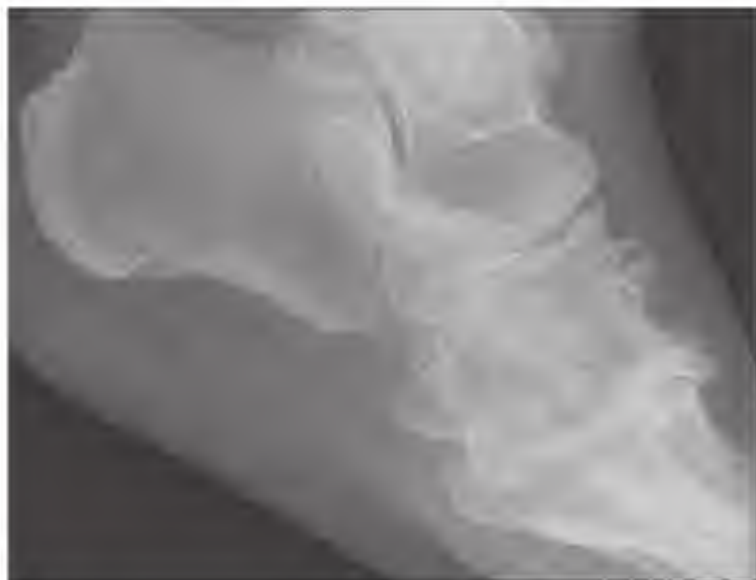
Midfoot radiograph showing hypertrophic osteoarthritis. Note the prominent osteophytosis typical of osteoarthritis with calcium pyrophosphate deposition.
